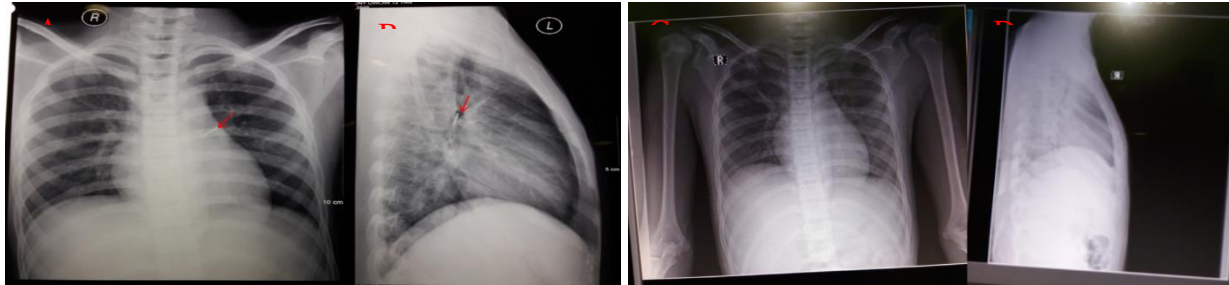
Comparison of Chest x-ray: A. Anteroposterior projection (AP) B. Left lateral projection (taken on 13<sup>th</sup> Februari 2017), Initial chest x-ray showed a spike shaped metal density on the left hilum at the level of 6<sup>th</sup> thoracic vertebrae. C. Anteroposterior projection (AP) D. Left lateral projection (taken on 17th Februari 2017) Chest x-ray after rigid bronchoscopy extraction, pulmos are normal and no foreign body found.
